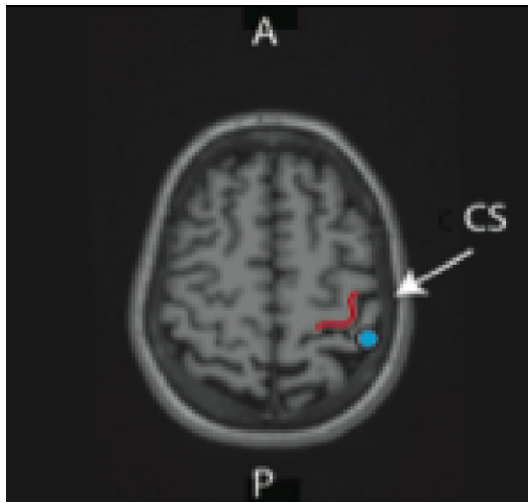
Localization of SI hand map. An example from one subject's data of the estimated SI ECD derived from the response evoked by a suprathreshold tactile stimulus to the left hand, third digit. The data localized to the SI hand representation in area 3b was confirmed by crosschecking with subjects' anatomical MRI identified with a red line outlining the omega shaped hand area in the central sulcus. Figure reprinted with permission from Jones et al. 2010.
